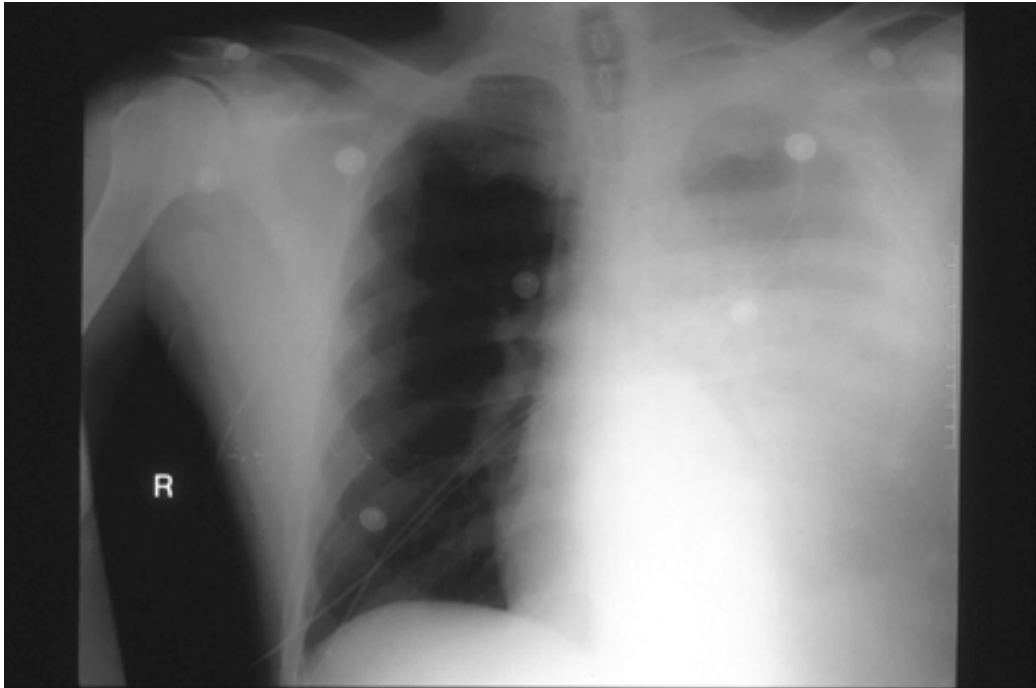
Portable anteroposterior radiograph of the chest showing interval development of large left pleural effusion.
